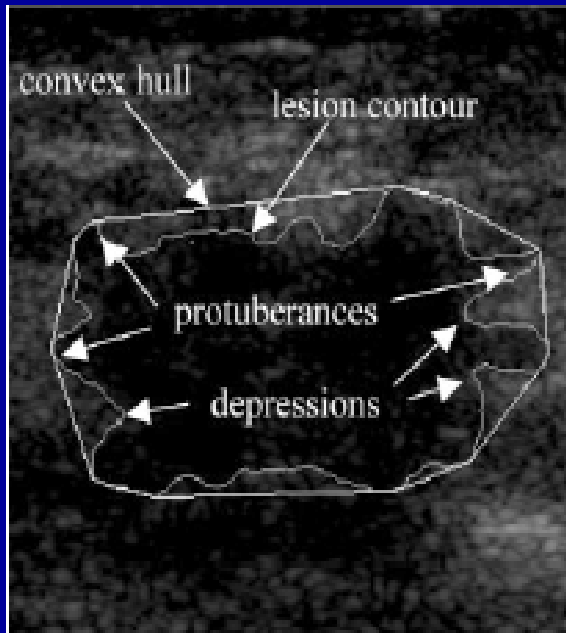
Sonogram shows the inner gray contour as the lesion border and the outer white polygon as the convex hull of the lesion. Protuberances and depressions in the malignant breast lesion are indicated.
